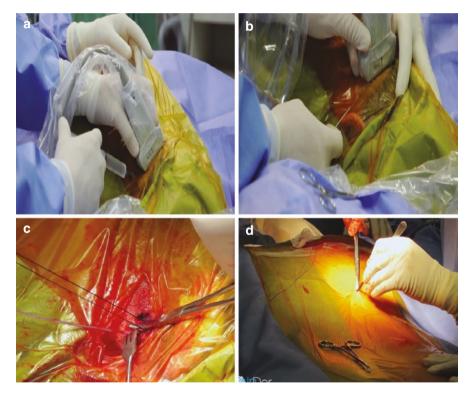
(a) Patient positioned in the prone position for occipital nerve electrode under general anesthesia and guided by ultrasound. (a) Skin anesthesia. (b) Tuohy needle passage from lateral to medial. (c) Electrode fixation using silicone anchor in the fascial plane. (d–f) Electrode tunneling from occipital to IPG pocket in the buttock. (g–h) IPG extension connection and skin closing
